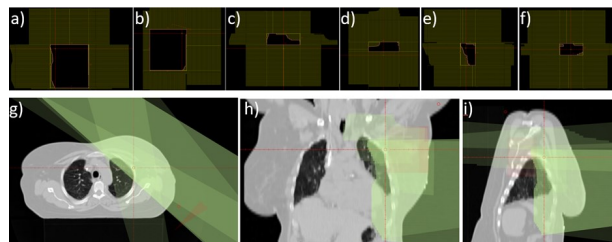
Beams' eye view of medial (a), lateral (b), supraclavicular (c), posterior (d), medial subfield (e), and posterior subfield (f), along with an axial (g), coronal (h), and sagittal (i) view of total beams on patient's planning CT images.
